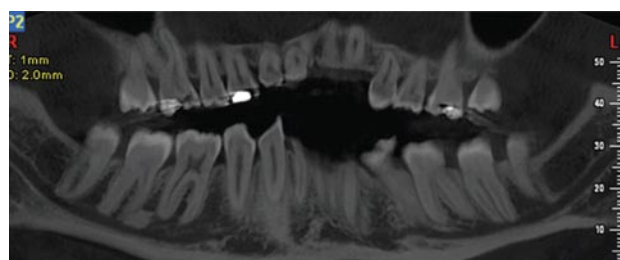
Reconstructed panoramic view using CBCT software displaying inferior alveolar nerve canal.
